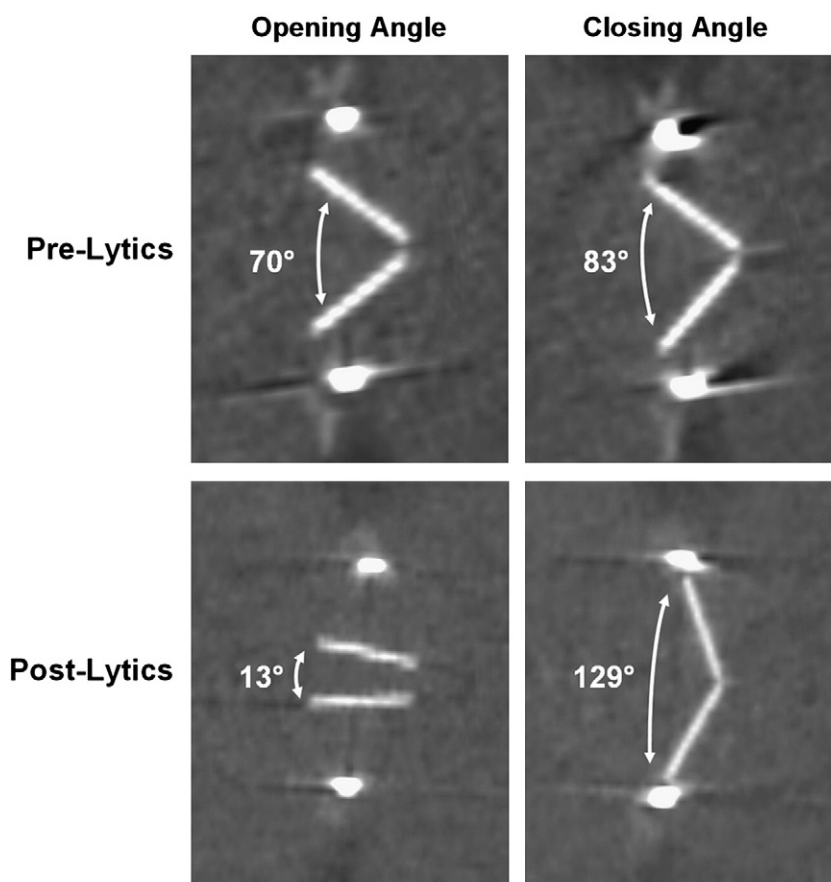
A. Initial cardiac CT of the heart before thrombolytic therapy, demonstrating minimally mobile leaflets of the mechanical tricuspid valve. B. Follow-up cardiac CT of the heart post t-PA infusion therapy showing restoration of the mobility of the mechanical tricuspid leaflets, with opening and closing angles.
